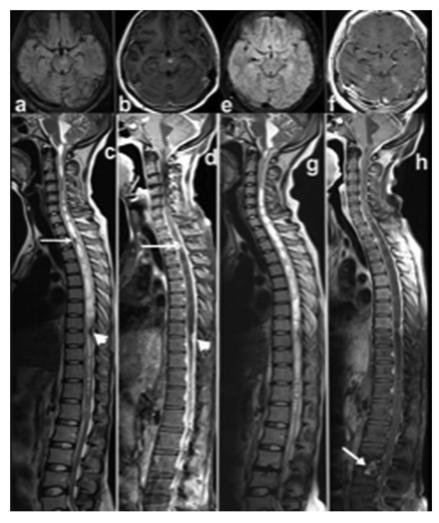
MRI brain axial FLAIR (a) and post-gadolinium T1-WI (b) shows enhancement in the interpeduncular cistern and diffuse pachymeningeal thickening and enhancement. Whole spine sagittal T2-WI (c) and post-gadolinium T1-WI (d) show holocord multiseptated CSF-like T2 -hyperintensity with thick leptomeningeal enhancement suggesting arachnoiditis with syrinx. T2-hypointense and peripherally enhancing subpial granulomas are present on anterior aspect of spinal cord at D2 (arrow) and posterior aspect of spinal cord at D8 (arrowhead) (c & d). Follow-up MRI brain axial FLAIR (e) and Post-gadolinium T1-WI (f) show significant decrease in enhancement. Follow-up MRI of whole spine-sagittal T2-WI (g) shows decrease in syrinx in upper cervical region and increase in syrinx in dorsal region. Leptomeningeal enhancement and enhancement of subpial granulomas has reduced in postgadolinium sagittal T1-WI (h). The enhancement of inferior endplate of L3 and superior endplate on L4 with intervening disc suggests spondylodiscitis and is a new finding (arrow in h).
